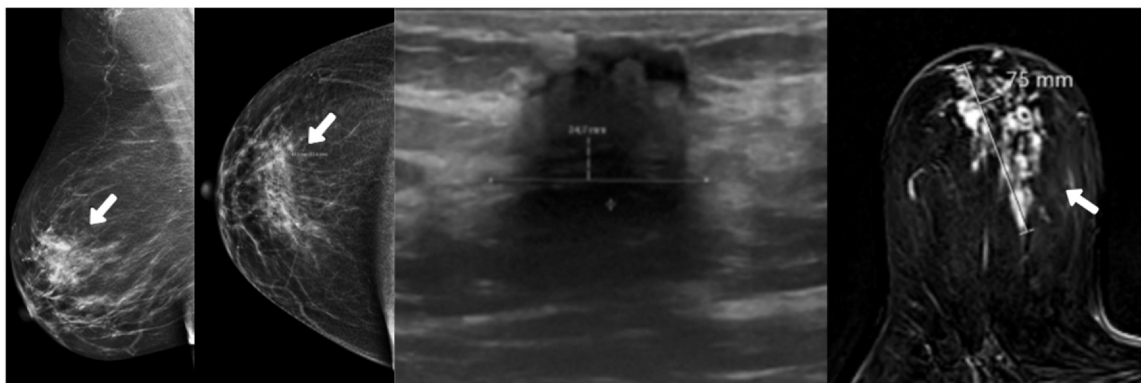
A 58-year-old woman had a 42 mm focal asymmetry on screening MMG (arrow). A 25 mm heterogeneous non-mass hypoechoic lesion was observed on US and a 75 mm asymmetric segmental non-mass enhancement was observed on MRI (arrow). The postoperative pathology result was DCIS (high grade) with a size of 100 mm. It is noteworthy that in tumors that present as non-mass lesions such as DCIS, MRI is the most accurate for pathological tumor dimensions.
